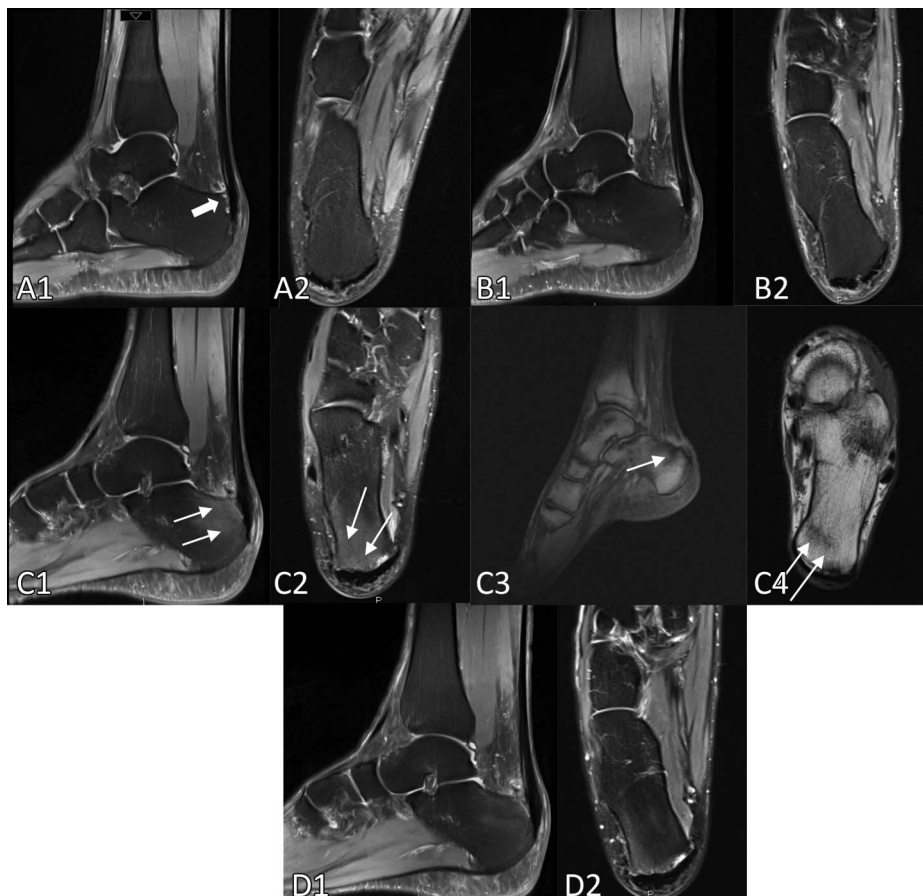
Images (MRI) of the development and resolution of CBB after successful resection of Haglund deformity (1 = sagittal; 2 = axial): (A) preoperative (arrow = bony prominence); (B) one-month postoperatively (no CBB); and (C) three months postoperative, at the time for the diagnosis of CBB (T1-images and T2-images, arrows showing CBB, C1-C4), pain started while patient was running in the snow. D, Six months postoperative, pain-free, symptomless and healed CBB.
